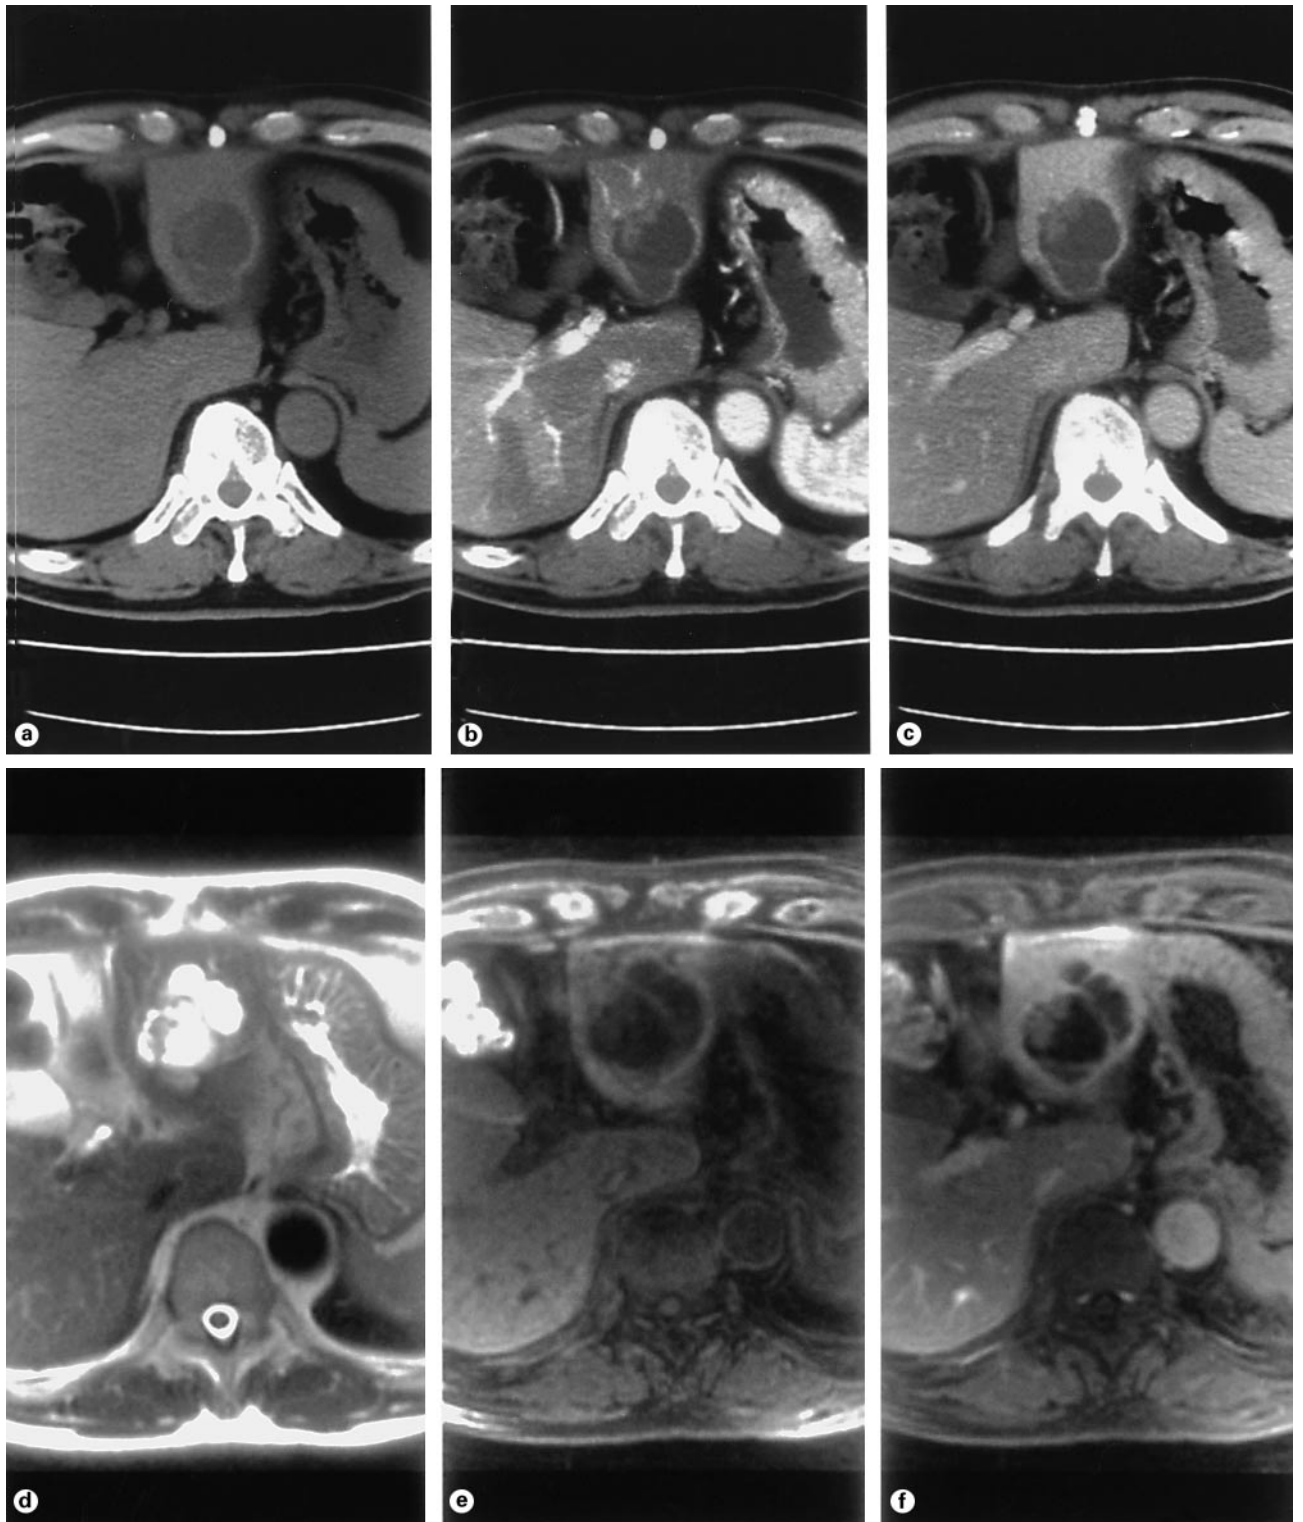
Biliary cystadenocarcinoma in a 64-year-old man. Unenhanced (a), arterial phase (b), and portal venous phase (c) images of dynamic helical CT show a multilocular cystic mass with enhanced papillary projection in the left lobe of the liver. The tumor shows a high signal on T2-weighted MRI (HASTE, TE = 64) (d) and a low signal on T1-weighted image (gradient echo, 4.4/1.8/20) (e). Septa and papillary projection are enhanced on contrast-enhanced T1-weighted image (f).
